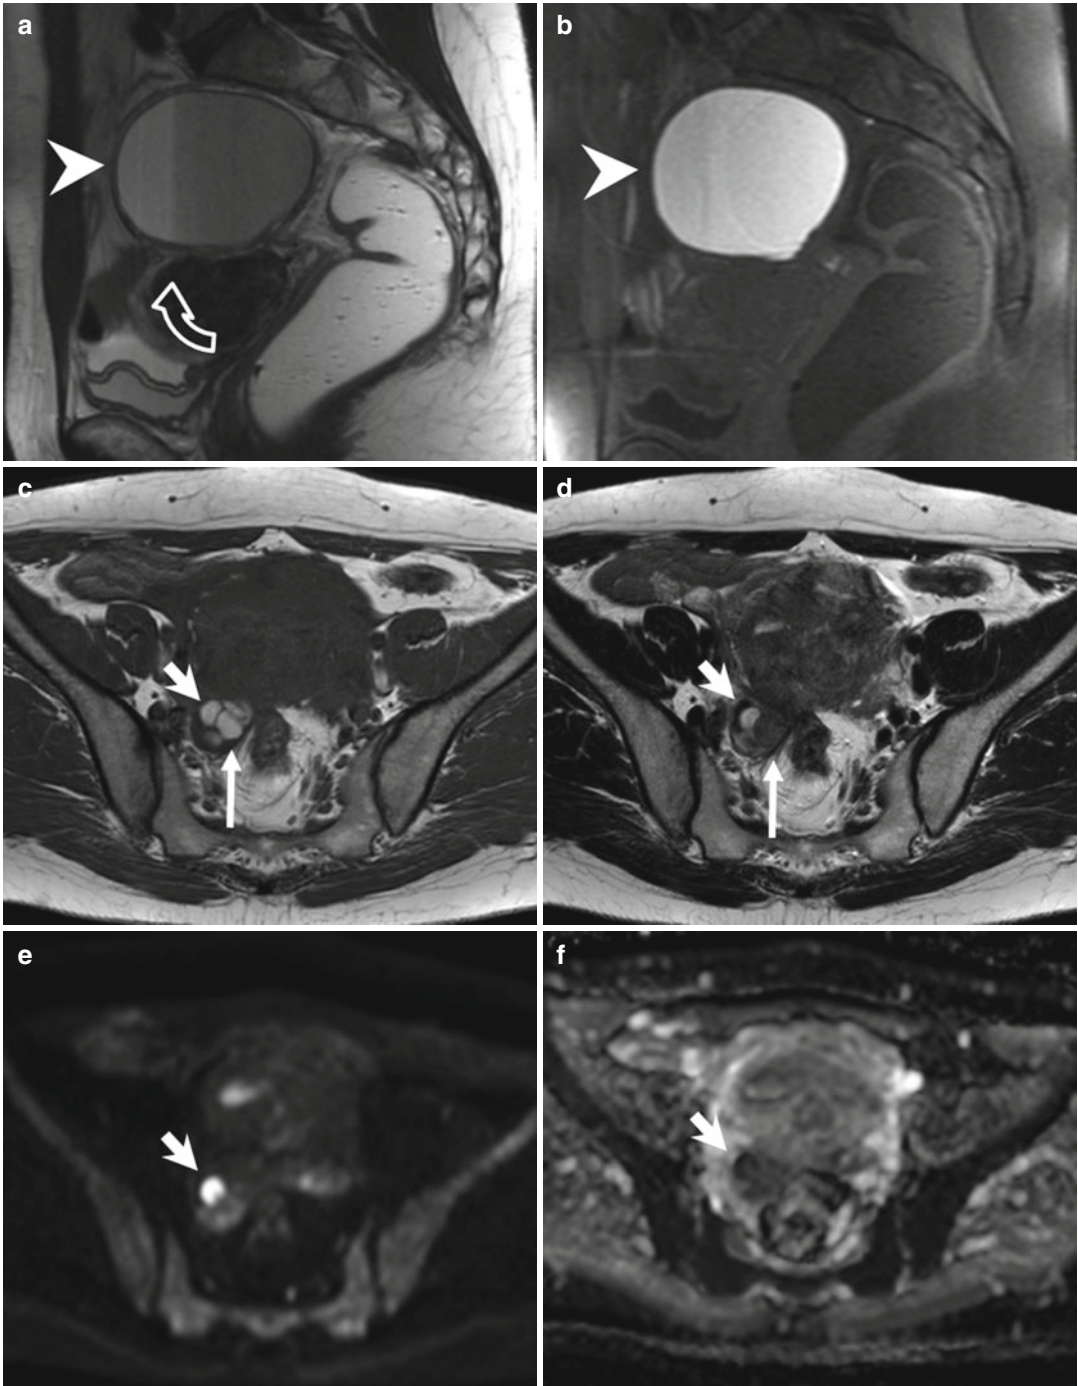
Large endometrioma (a, b). Sagittal T2- (a: TR 4530, TE 90) and T1-FS-weighted (b: TR 328, TE 11) images show a large adnexal cystic lesion (arrowheads) with fluid-fluid level (a: curved arrow). The dependent component appears hyperintense on T1-weighted image with fat suppression (b) and shows a marked T2-shading effect (hypointensity on T2-weighted image). Small endometriomas (c-f). Axial T1-weighted FSE MR image (c: TR 640, TE 10) shows multiple small T1-hyperintense cystic lesions in the right ovary. Axial T2-weighted FSE MR image (d: TR
